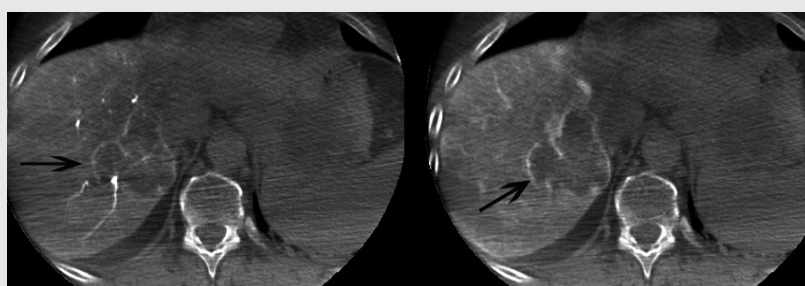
dual-phase cone-beam CT before chemoembolization reveals predominant right-sided colorectal liver metastases (arrow) with central necrosis.
